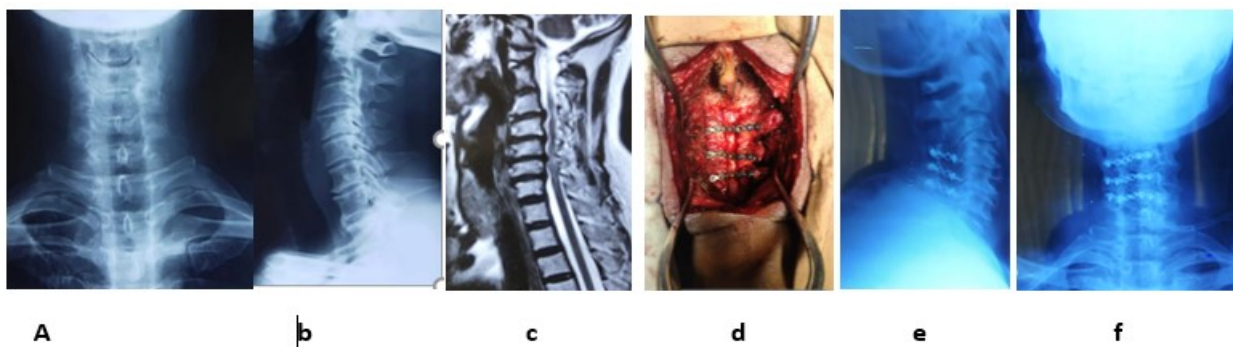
49-year-old male, diagnosed spastic quadriplegia (a, b) plain X-ray cervical spine A-P and lateral view shows multilevel cervical spondylosis (c) sagittal section T2 weighted MRI shows MCSM compressing the cord at C3/4 to C5/6 (d) per operative picture (e,f) x-ray lateral and A-P view at 12 months after laminoplasty.
